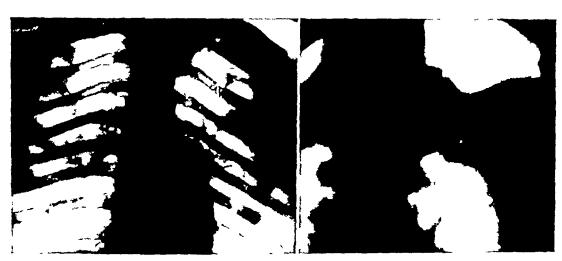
Routine radiographs does not rescal infiltrat in at the right pex.
